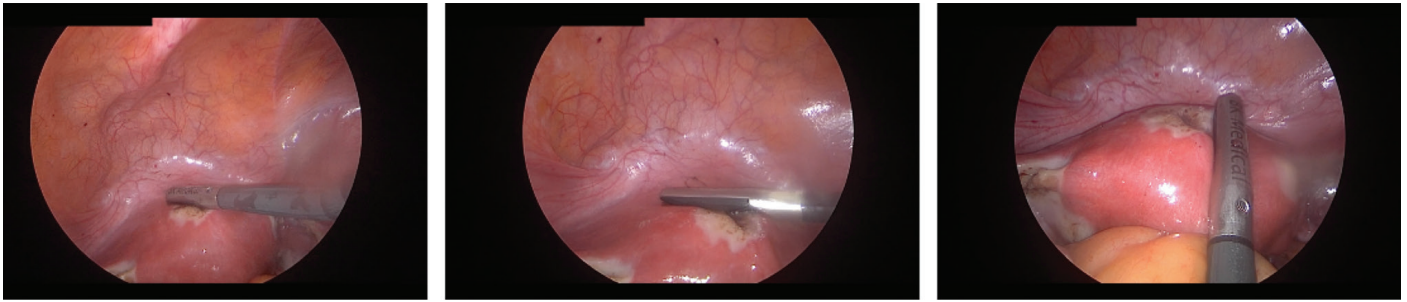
Intraoperative laparoscopic ultrasound during laparoscopic myomectomy surgery
